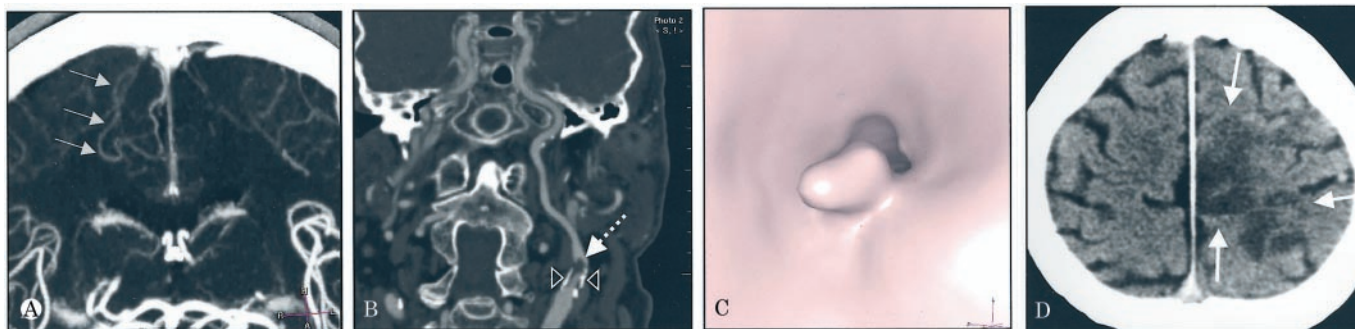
Cerebral multislice CT angiography (MS-CTA): normal peripheral anterior cerebral artery (ACA) branches on the right side (arrows), hypoperfusion of corresponding contralateral branches (A). Cervical MS-CTA: left internal carotid artery stenosis (B) with clarification (arrowheads) and intraluminal thrombus (dotted arrow); endoluminal view shows apex of the thrombus (C). (D) Noncontrast head CT: cortical ACA infarction affecting the paramedian front and the parietal lobe (arrows).
